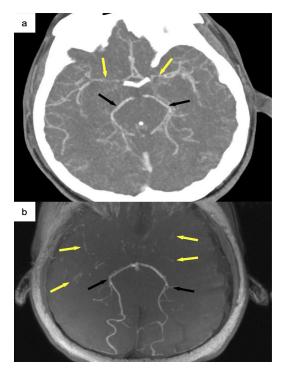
(a) CT angiography of the head, 3D MIP axial reconstruction, demonstrating attenuation of the bilateral middle cerebral arteries (yellow arrows) as compared to the posterior circulation (black arrows). (b) MR angiography of the head, 3D MIP axial reconstruction, demonstrating absence of flow-related signal intensities in the anterior circulation of the Circle of Willis. Nearly non-perceptible signal observed within the segments of the bilateral middle cerebral arteries (yellow arrows). Normal flow is present within the posterior circulation (black arrows).
